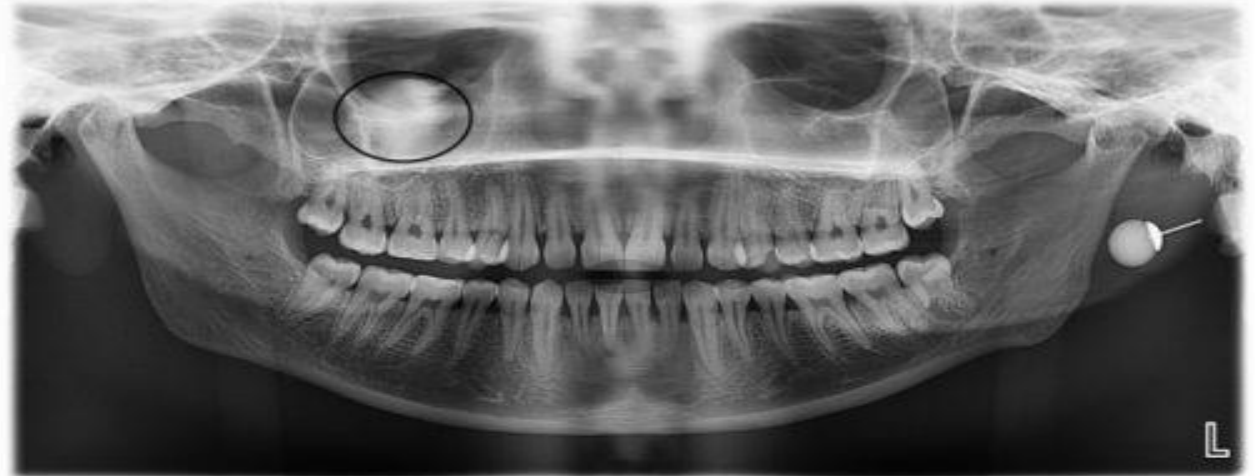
Panoramic radiograph with a ghost image from an earring. The real image of the earring is visible on the left side, while the ghost image is superimposed over the right maxillary sinus area.
